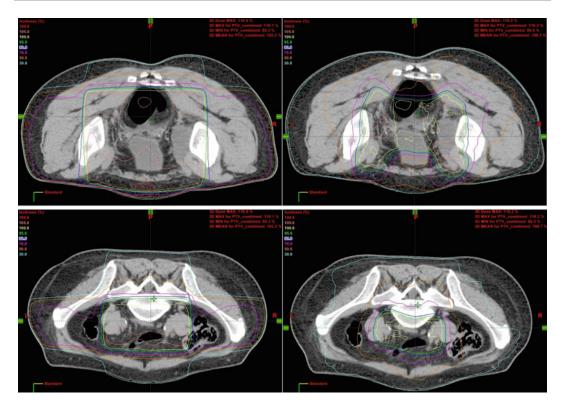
Axial CT images with isodose distributions for conventional four-field (*left*) and IMRT (*right*) plans. The 50 % (*orange*), 70 % (*pink*), and 100 % (*yellow*)
